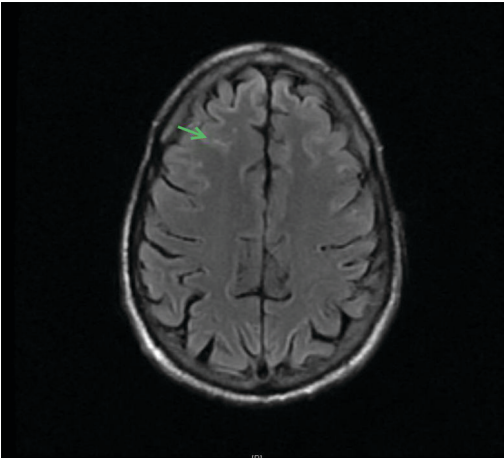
Subtle areas of sulcal T2/FLAIR hyperintensity along the right frontal sulci can be seen in the setting of meningitis.
